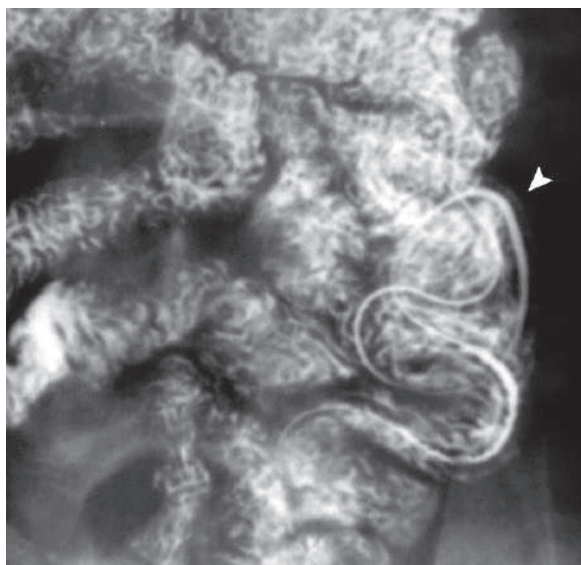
Barium enteroclysis radiograph of a patient with ascariasis shows a long, tubular filling defect in the jejunum, with a double contrast sign representing ascaris worm with barium ingestion (*arrowhead*)
